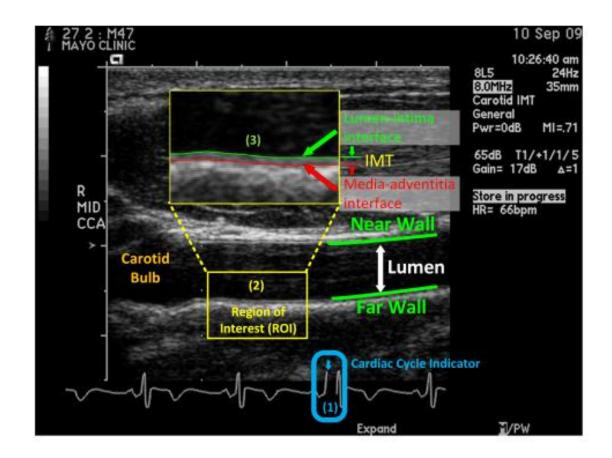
Longitudinal view of the common carotid artery using an ultrasound B-scan *image*. Taken from Shin et al., 2016.
